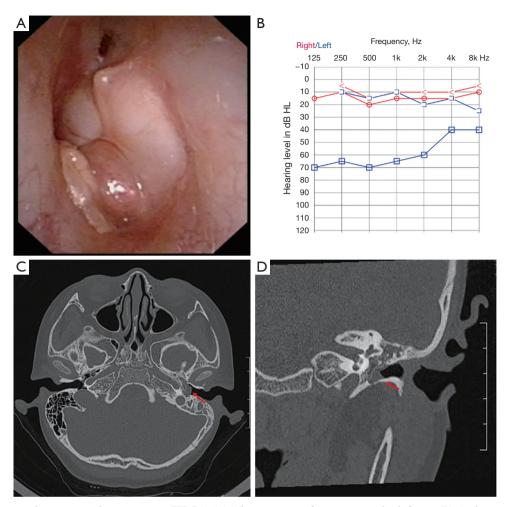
Otoscopy, audiograms, and preoperative HRCT. (A) The outcome of otoscopy in the left ear. (B) Audiograms of the patient. The air conduction results are represented by the blue "\(\sigma\)" in the left ear and the red "\(\circ\)" in the right ear. The bone conduction results are represented by the blue "\(\sigma\)" in the left ear and the red "\(\circ\)" in the right ear. (C) In the axial images, the red arrow represents an irregular soft tissue density mass with significant strip calcification. (D) In the coronal images, the red arrow represents a slightly rough surface of the bone in the inferior tympanic cavity. HRCT, high-resolution computed tomography.
